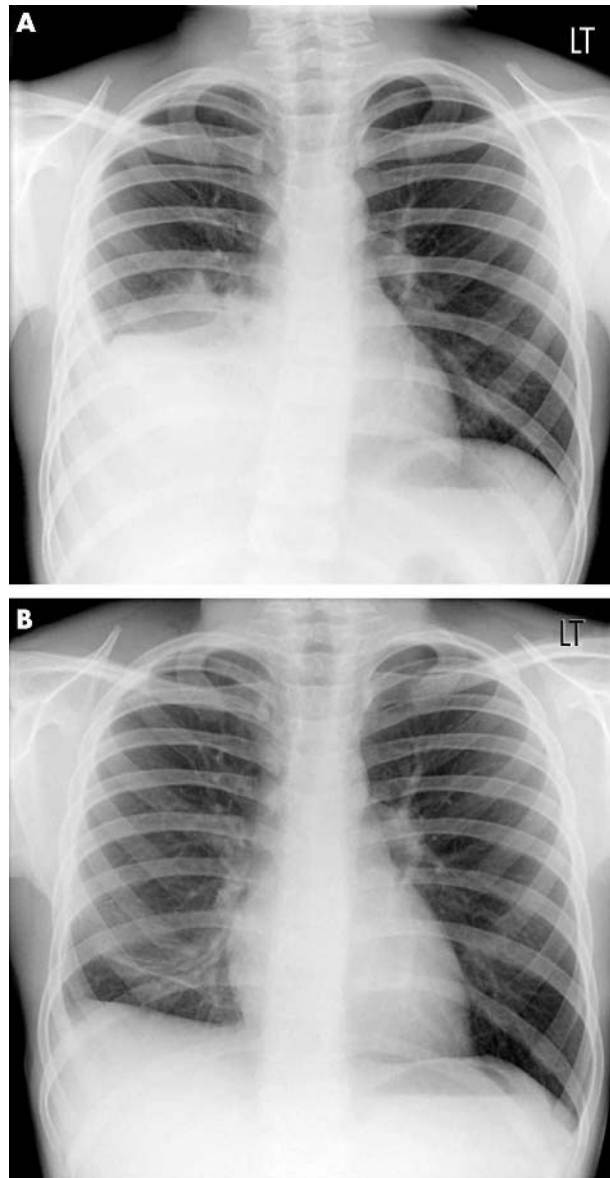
Case 4: Initial and follow up chest radiographs.
